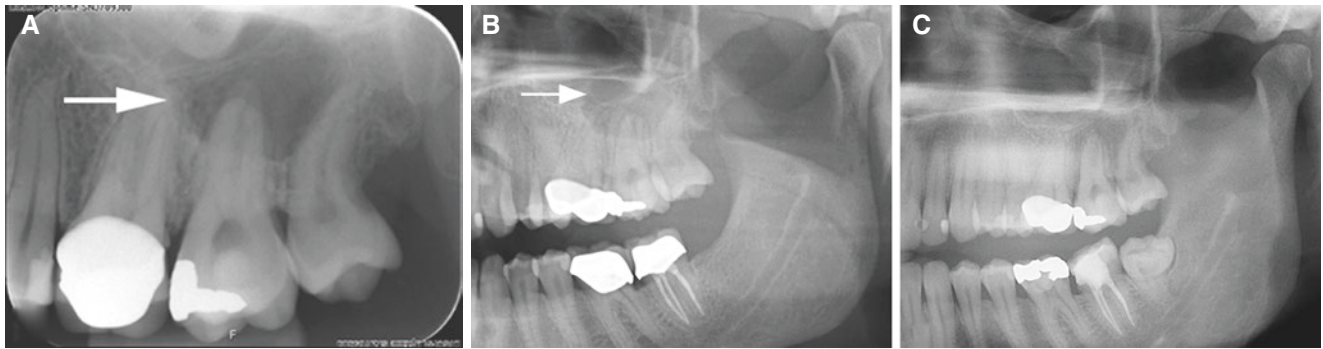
Periapical cyst development, maxilla; 32-year-old female with some discomfort and palatal swelling in left molar region. (A) Intraoral view shows periapical radiolucency at second molar (*arrow*).
